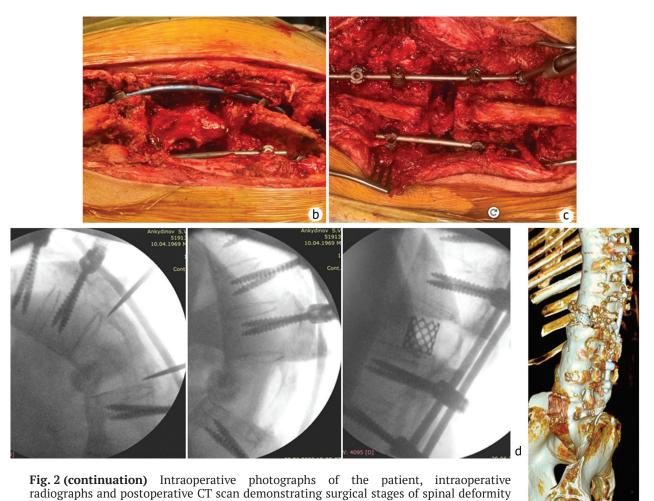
Intraoperative photographs of the patient, intraoperative radiographs and postoperative CT scan demonstrating surgical stages of spinal deformity correction showing (a) the patient positioned on the operating table before and after surgery, visual regression of kyphosis noted
